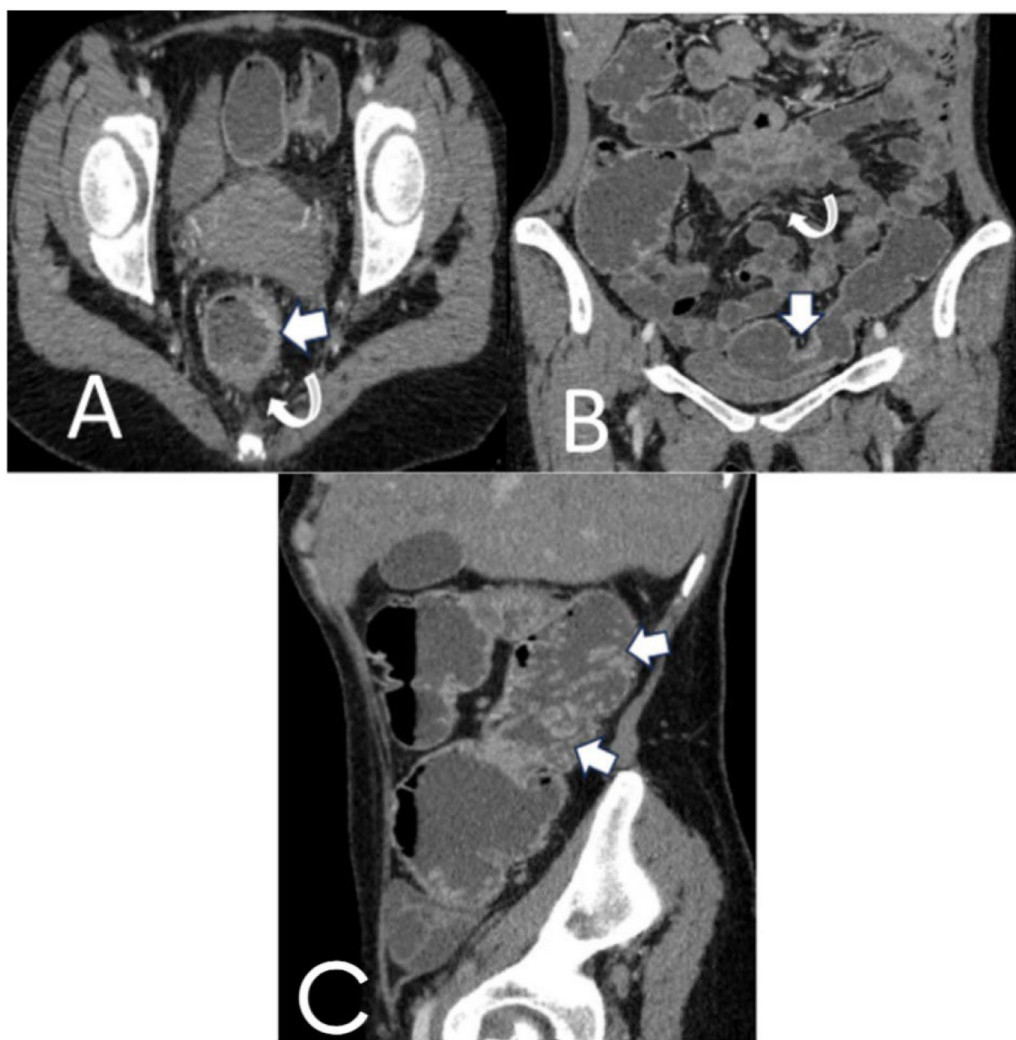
CT enterography with IV contrast (A) axial image shows uniform circumferential mural thickening of rectal wall with mucosal hyperenhancement (arrow) with perirectal stranding and lymph node enlargement (curved arrow), (B) coronal image shows luminal narrowing in the sigmoid (arrow) and mesenteric vascular engorgement (curved arrow) and (C) Sagittal reformatted image shows mild mural thickening and mucosal hyperenhancement of ascending and transverse colon with multiple pseudopolyps (arrows). *CTE score: 11. Modified Mayo score: 7*
